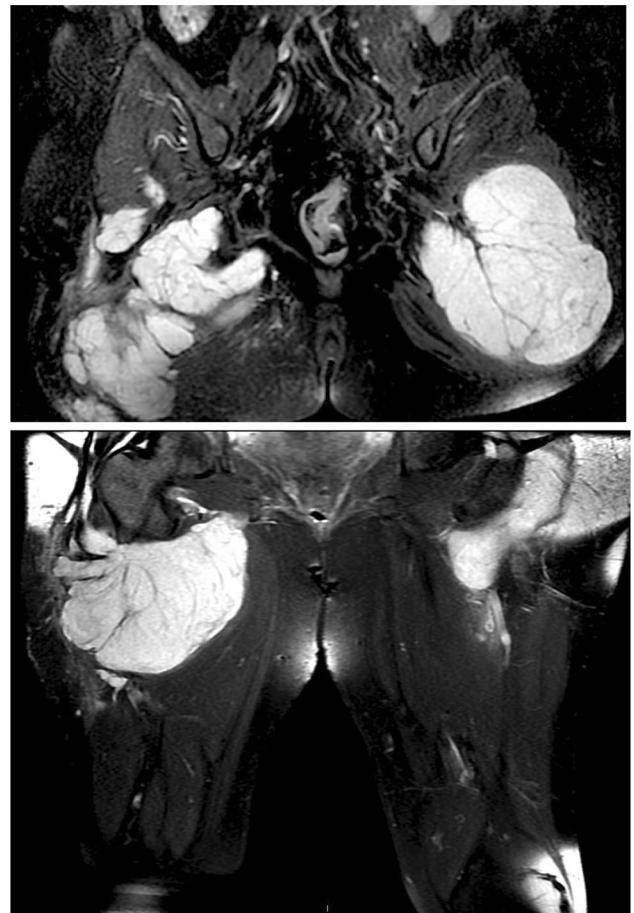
Axial and coronal MRI showing the preoperative extension of the tumor in the buttocks bilaterally
